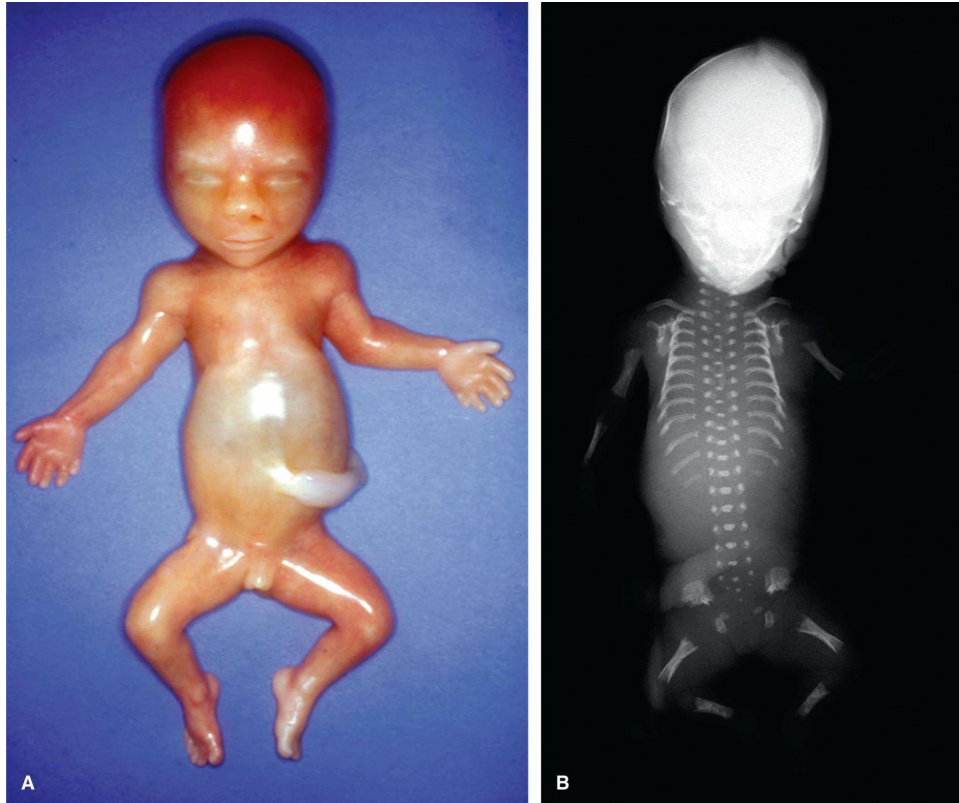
Short-rib polydactyly syndrome (also known as short-rib thoracic dysplasia). (A) The chest of the fetus is narrow, and postaxial polydactyly affects all four limbs. (B) As seen in this x-ray, the ribs of the fetus are very short.
